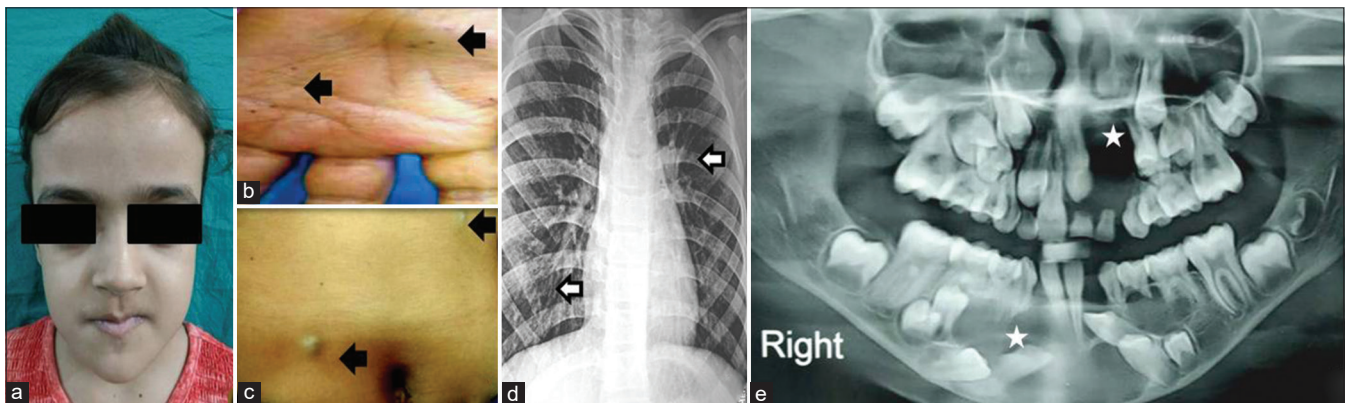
Case 1 is a 9-year-old girl showing (a) extraoral clinical photographs with hypertelorism (b) Palmar pits (c) Dermal nodules (d) Bifid rib (e) orthopantomogram revealing multiple radiolucent lesions (white asterisk)
